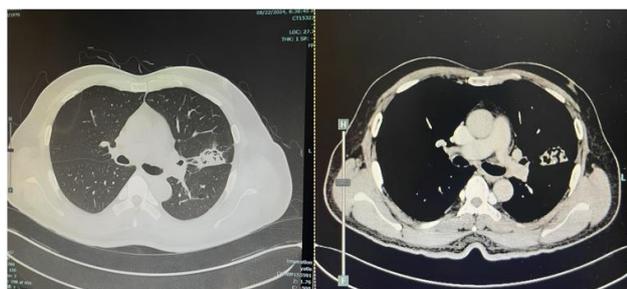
The HRCT thorax, axial view, revealed a thick, non-enhancing cavity that appears connected and surrounded by the dilated bronchi, measuring $1.9 \times 2.3 \times 2.1$ cm (arrow) & presence of non-enhancing soft tissue density within this cavity measuring $1.0 \times 1.3 \times 1.6$ cm, likely keeping with aspergilloma (arrow) (Reprinted with permission of the patient)
